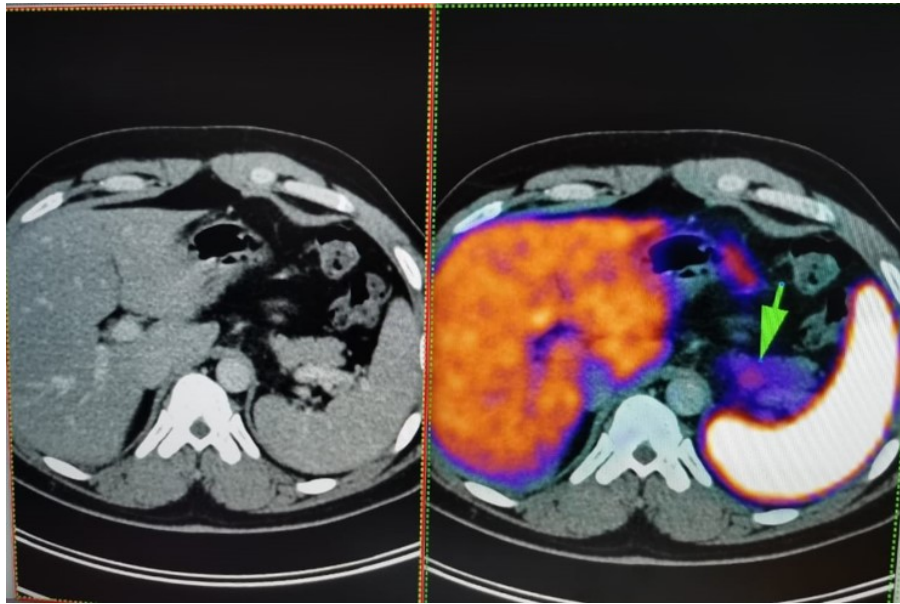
Gallium Dotatate PET-CT showing avid nodule in the distal pancreatic region separable from the spleen
